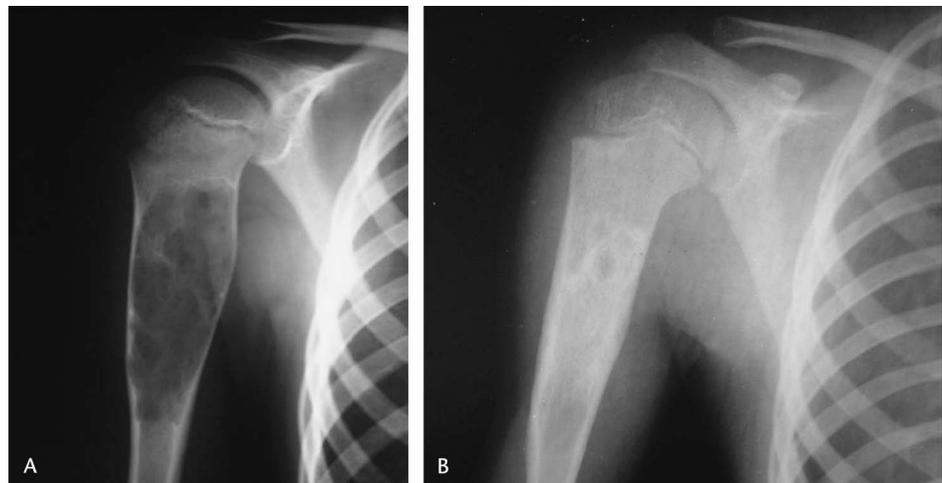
A, Admission radiograph of a 4.5-year-old boy. B, Same patient, 23 months after surgery.
